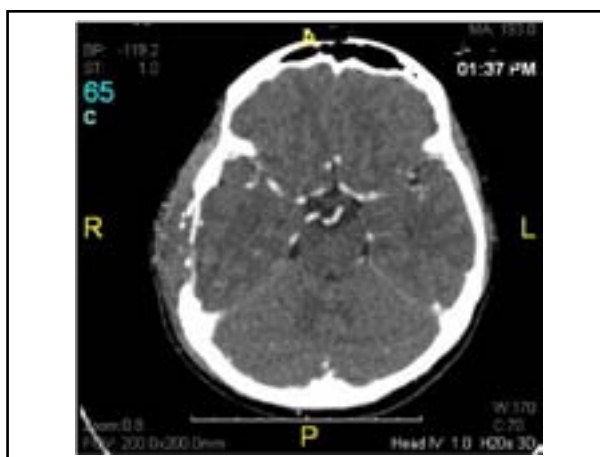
Axial CT scan of the temporal bone two weeks after incision and drainage and antibiotic administration demonstrates resolving abscess at both subperiosteal and adjacent extradural of right temporoparietal area. Bony destruction was the same.
